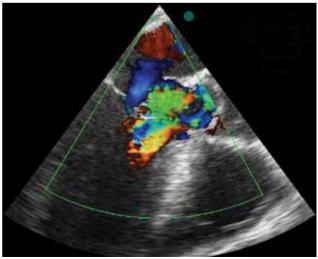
Intraoperative transesophageal echocardiography image shows severe aortic regurgitation.
